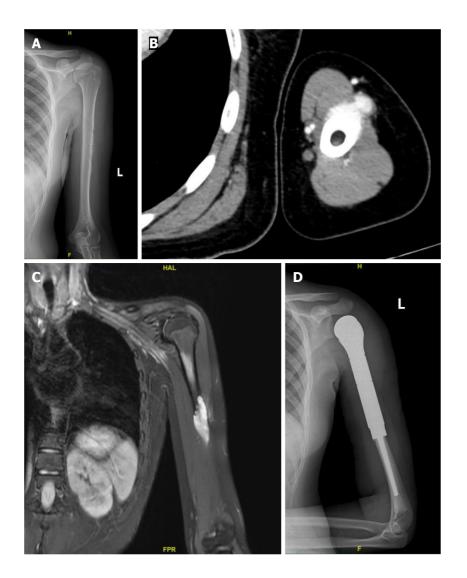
Imaging findings of the lesion. A: X-ray reveals bone destruction and thinning of the corresponding segment of the cortical bone in the midshaft of the left femur; B: Computed tomography scan reveals roughness of the cortical bone in the middle segment of the left humerus, with surrounding soft tissue masses exhibiting a nodular morphology; C: Magnetic resonance imaging reveals a soft tissue mass surrounding the left humerus, which appears as a high signal on diffusion-weighted imaging; D: The postoperative X-ray indicates the presence of metallic internal fixation material in the surgical area of the left humerus.
